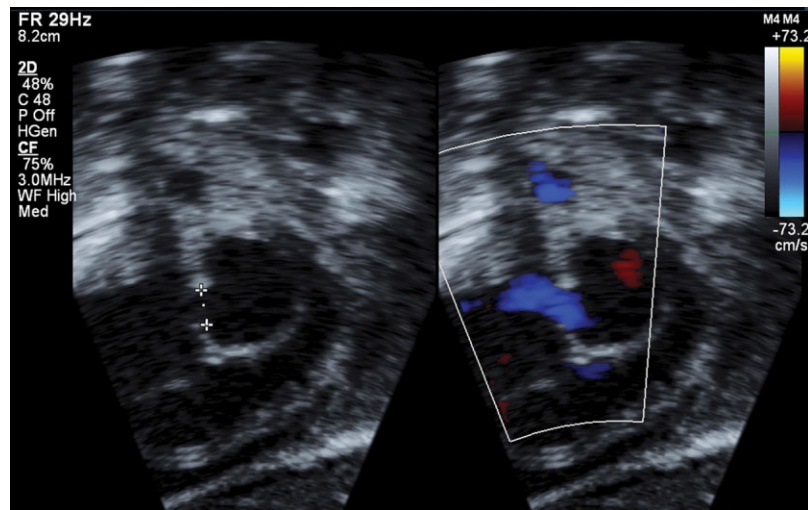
Transthoracic 2D echo with and without color flow mapping after Rashkind balloon atrial septostomy documenting an enlarged atrial septal defect (4.3 mm) with low velocity flow (mean gradient 2 mm Hg).
